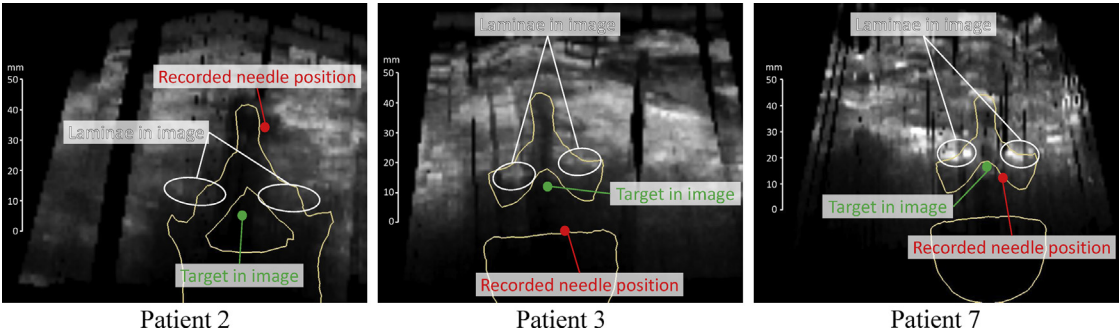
Qualitative assessment of epidural cases for which anatomical information could not be provided accurately (P2, P3, P7; cf. Fig. 4). An expert sonographer delineated laminae (*white ellipses*) and the target area (*green circle*) in the target ultrasound plane of the volume, which is shown along with the recorded tip position of the needle (*red circle*) and the overlay of the statistical 3-D surface model of the lumbar spine.
